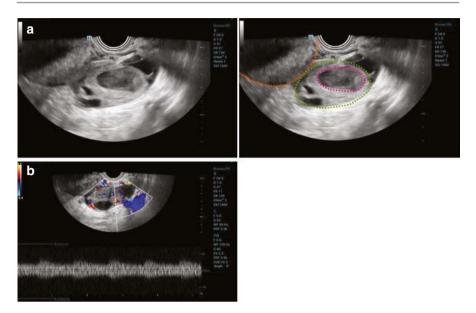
(a) Ovarian abscess on B-mode ultrasound showing a thick-walled cystic mass with poor sonolucency and dense, fine, punctate echoes within the mass. The uterus is outlined in orange; the ovary is circled in green; the ovarian abscess is circled in pink. (b) Doppler ultrasound reveals an arterial spectrum in the wall of the mass
